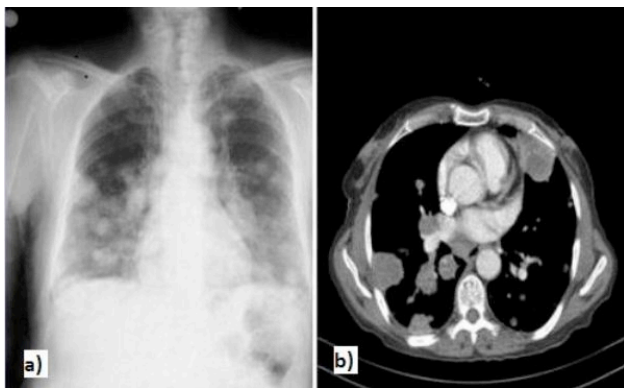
Diffuse nodular lesions on chest radiograms (a), On thoracic computed tomograms bilateral and multiple hypodense soft tissue lesions with central necrosis were seen on lungs and hilar regions the largest ones measuring 5.3x3.6cm on the right and 5.2x3cm on the left side (b).
